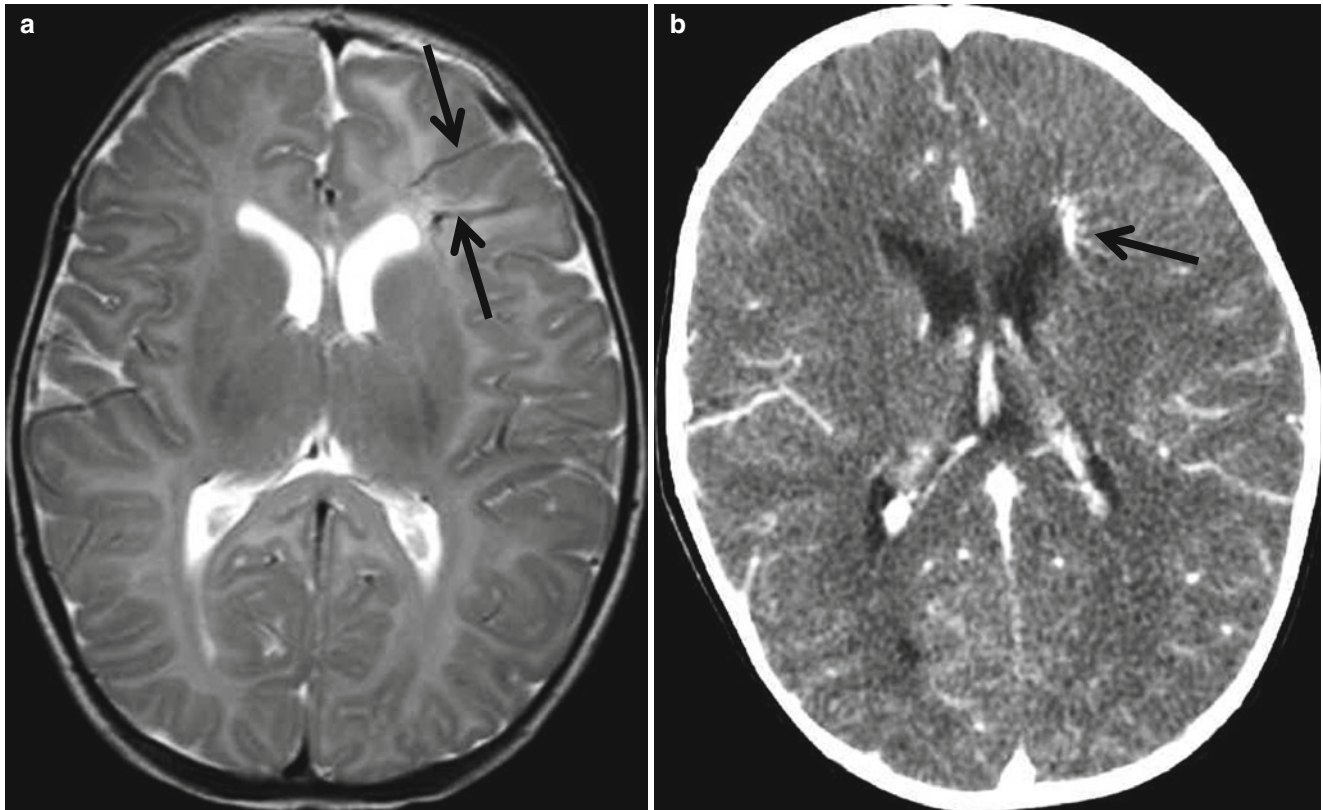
Developmental venous anomaly. (a) T2-weighted image shows localized hyperintense parenchymal lesion in the left frontal lobe and multiple vessels (*arrows*). (b) Postcontrast CT demonstrates enhancing tuft of radially arranged vessels (*arrow*)
